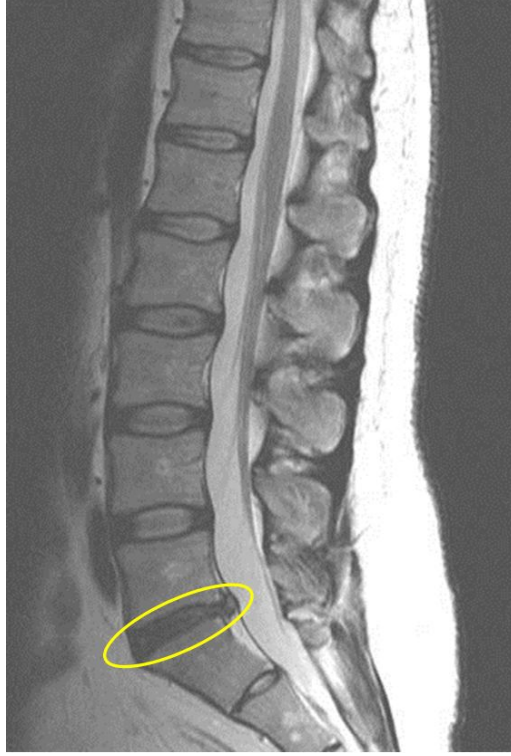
Mid-sagittal MR image of the lumbar spine with herniated disc. The herniated disc (circled) is much darker in appearance and has a posterior bulge. (From Wang (2009) [56].)
